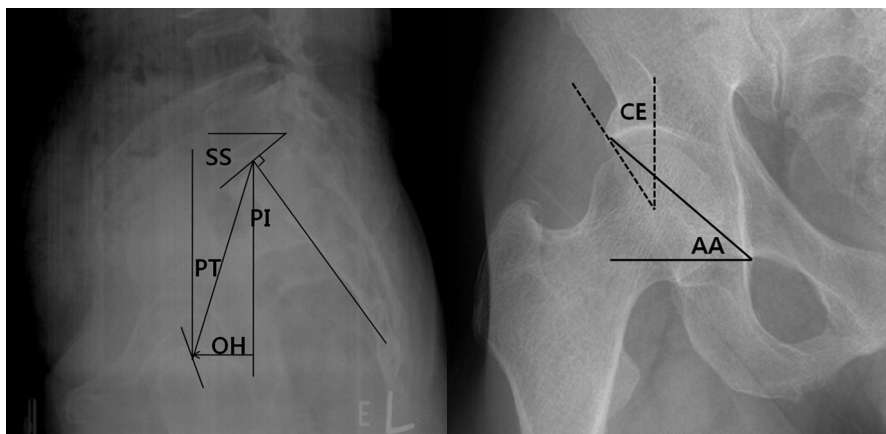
Plain radiographs showing (Left) sagittal pelvic and (Right) coronal hip parameters.
